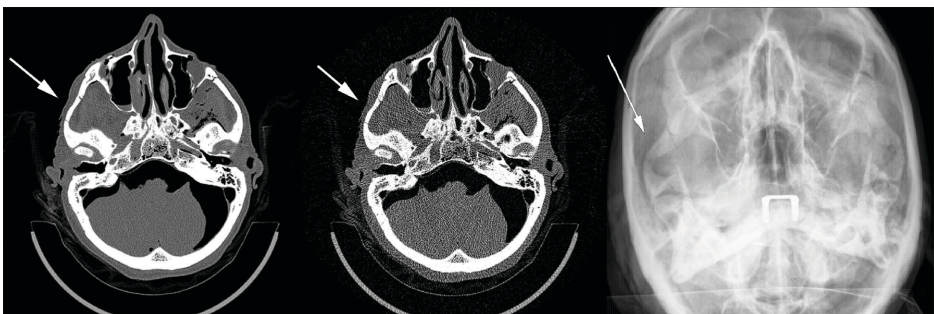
Randomly paired comparison of a CT- and DR image of the same fracture. Representative examples of CT, minimal dose CT and DR images of a zygomatic fracture (arrows). The rater was forced to select either the CT or the DR image of the same fracture in which the fracture was better visualized.
